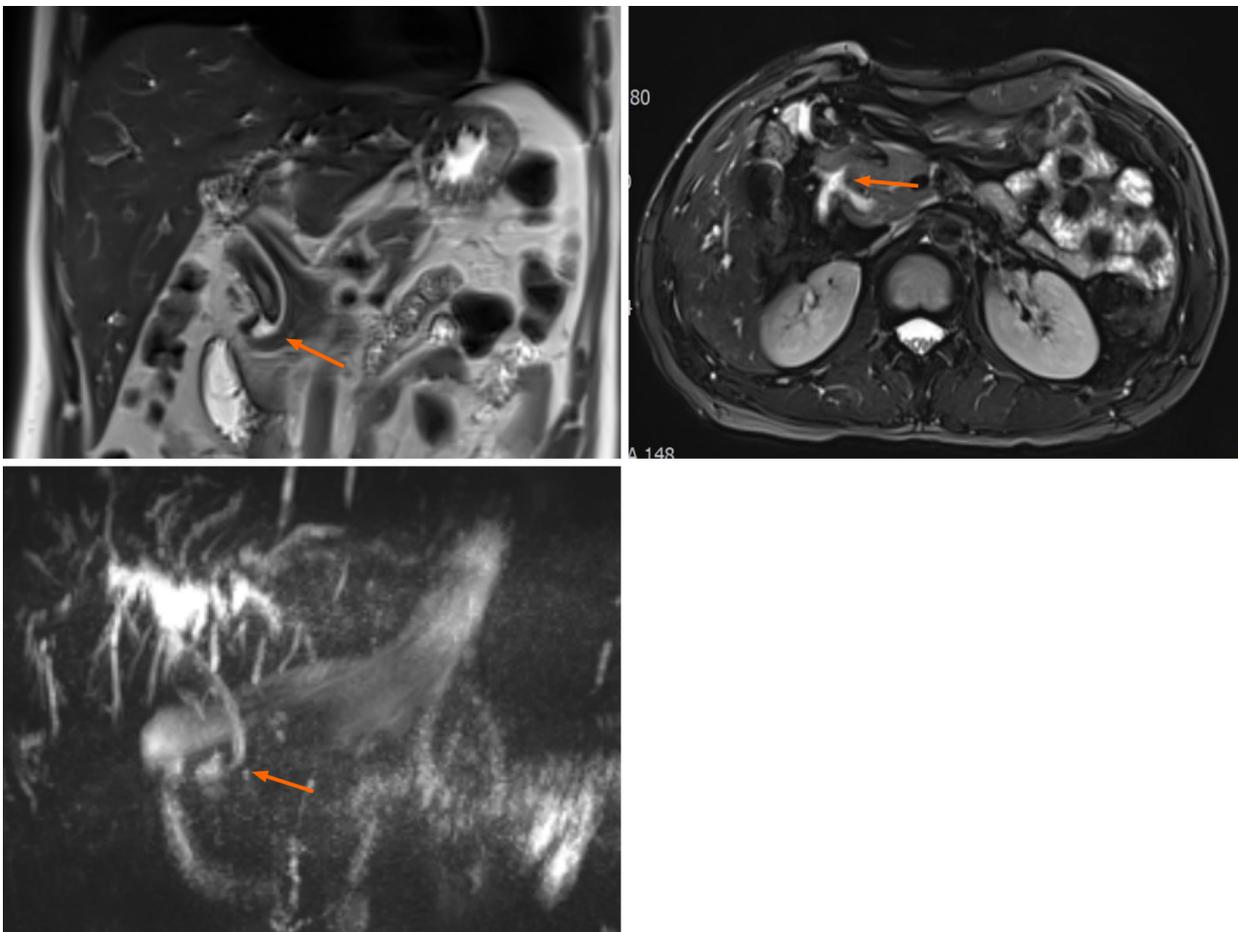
Magnetic resonance imaging findings. Magnetic resonance imaging showed a hook-shaped change at the lower end of the common bile duct, which merged into the lower posterior wall of the duodenal bulb. The orange arrow shows the hook shape.
